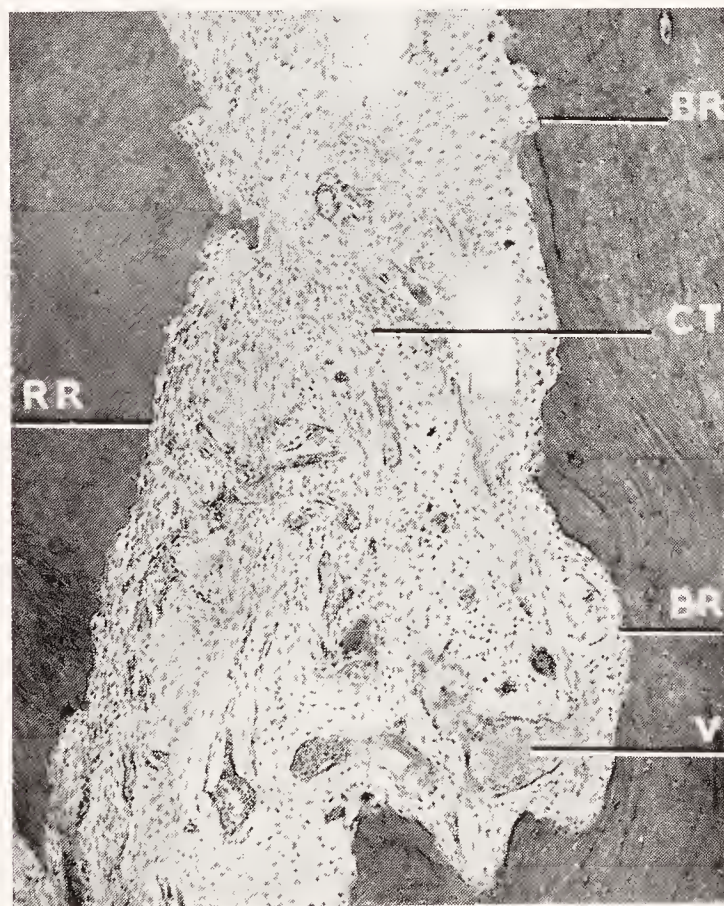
High magnification of a portion of the root surface near the apex in Figure 310. *RR*, resorbed dentin surface; *CT*, loose connective tissue; *V*, blood-vessels; *BR*, bone resorption.
